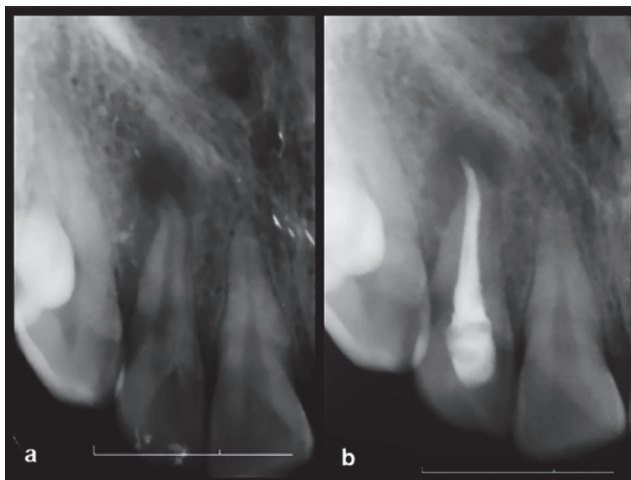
Periapical radiographs of right maxillary lateral tooth before (a) and after (b) endodontic treatment
